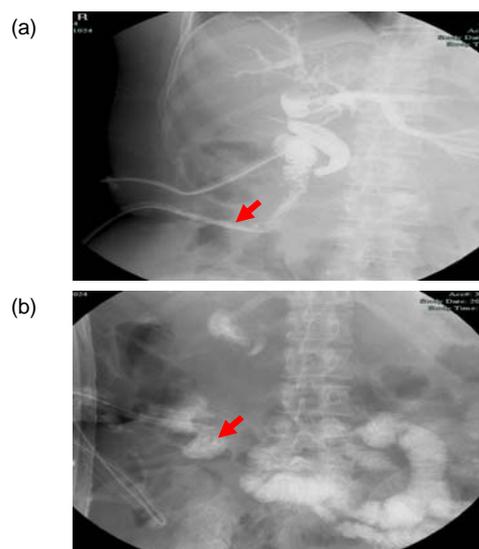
Radiographies of T-tube (a) and drainage tube (b)
